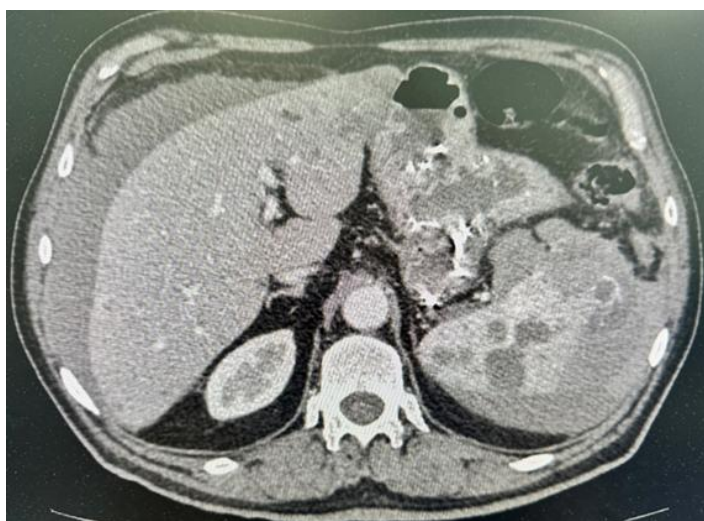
Abdomen CT scan demonstrating multiple splenic lesions, splenic rupture and intraperitoneal effusion.
